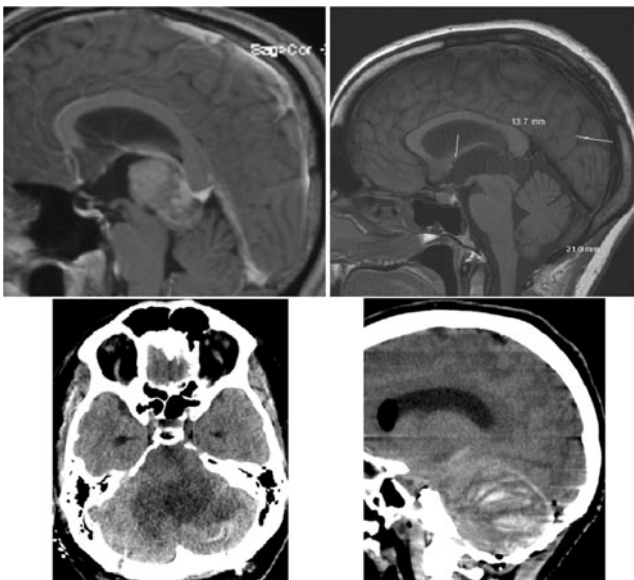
To the *left*, pineocytoma preoperative MRI and postoperative CT. A significant swelling is seen on postoperative CT. To the *right*, pineal cyst seen on preoperative MRI and postoperative CT demonstrates hemorrhagic infarction
